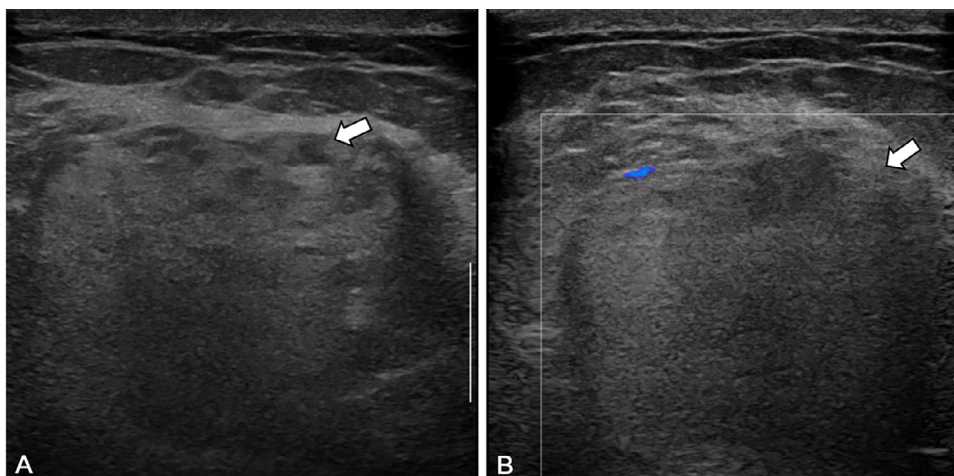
Ultrasound images. (A) The mass is an oval, parallel orientation and predominantly hyperechoic with focal cystic components (arrow). (B) The mass shows mild peripheral vascularity and partially indistinct margin (arrow).
